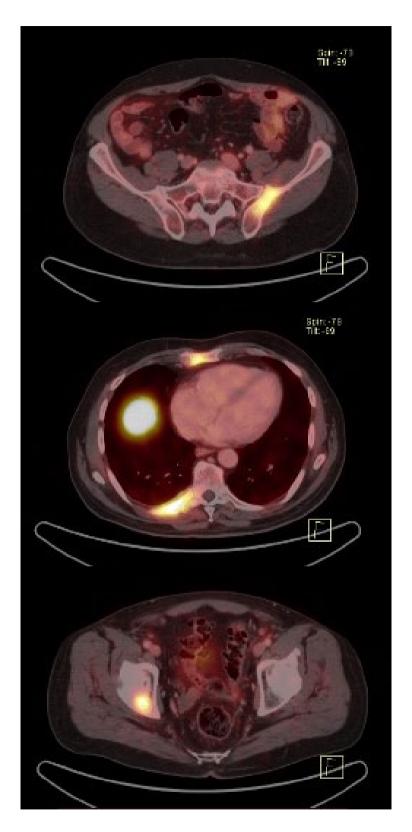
PET/CT PSMA with bone lesions showing abnormal PSMA overexpression, suggestive of secondary implants, located on the left iliac (A), sternum and right costal arch (B) and right iliac (C)
